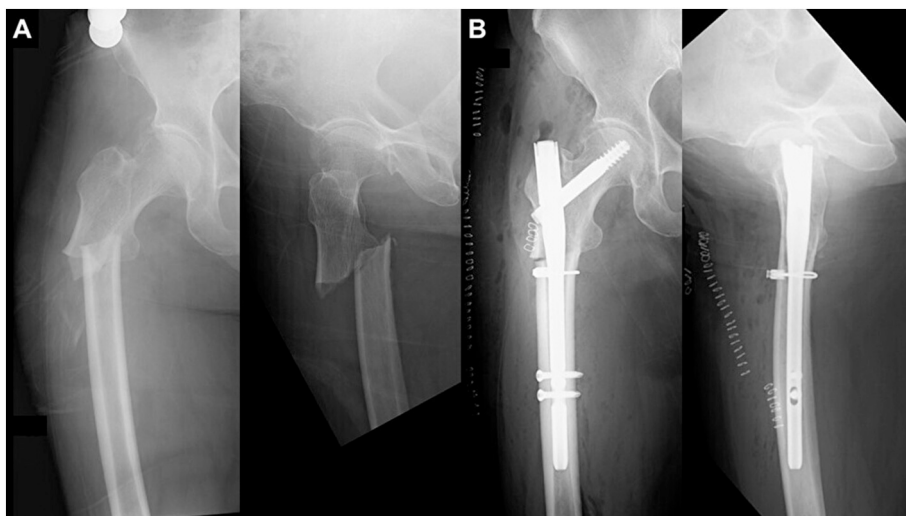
Pre- and post-operative radiographs of the right femur. (A) Plain radiographs show an atypical subtrochanteric femoral fracture with a transverse fracture line and medial spike. (B) The right femur is fixed using a mid-length intramedullary nail.
